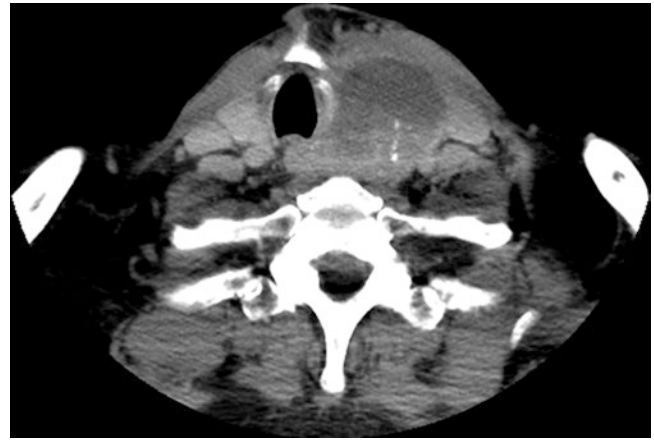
Axial computed tomography (CT) of the neck demonstrating a left-sided thyroid mass with invasion into the cricoid cartilage. This patient presented with a paralyzed ipsilateral vocal cord secondary to involvement of the recurrent laryngeal nerve
